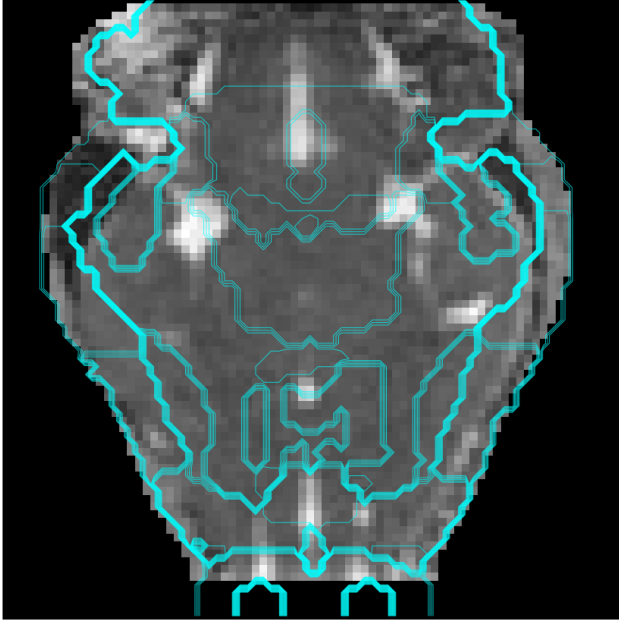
Representative quality control (QC) plot for brain atlas registration. The image shows a b0-weighted MR image of a bat brain with overlaid cyan contours from the co-registered anatomical atlas. This plot confirms accurate anatomical alignment, ensuring reliable extraction of regional brain morphometric features for subsequent analyses of age-related changes.
